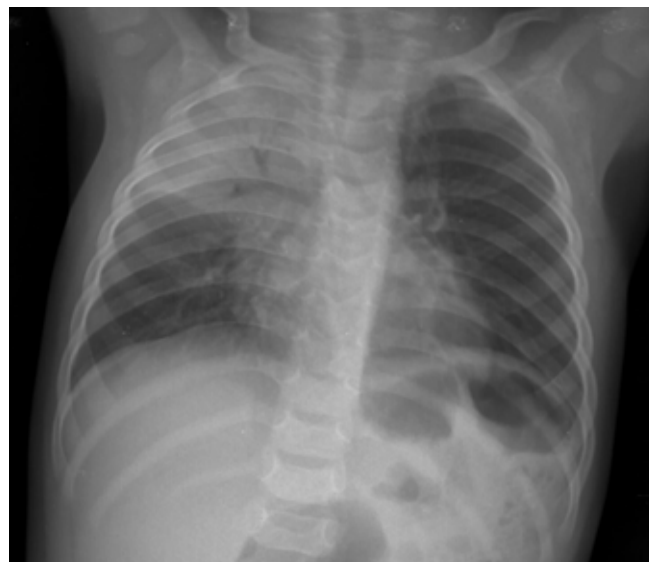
Chest X-ray of an Infant of 11 months, antero-posterior projection, showing a right upper lobe opacity, confluent, with well-defined margins and air bronchogram. The heart shape and size are normal. There is no pleural effusion.
